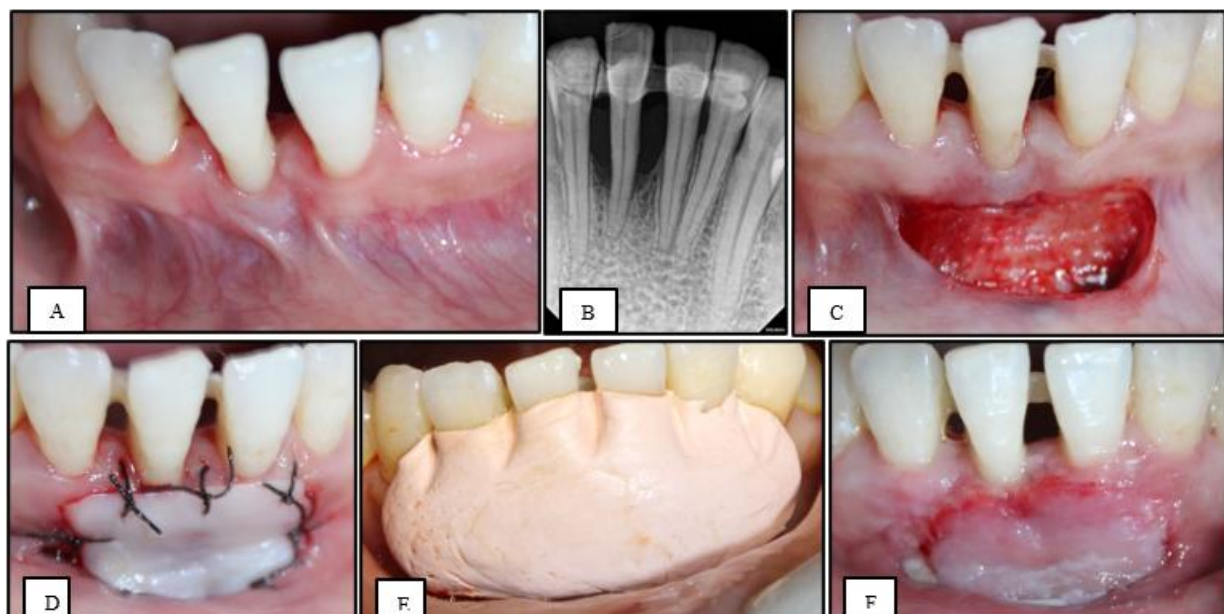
A)-preoperative photograph; B)-radiograph showing intrabony defect; C)-vestibular extension done; D)-palatal FGG harvested and placed at the recipient site, sutured with 4-0 silk suture; E)-periodontal dressing given; F, G, H)-post-operative view at 1 week, 3 months, and 6 months respectively.
